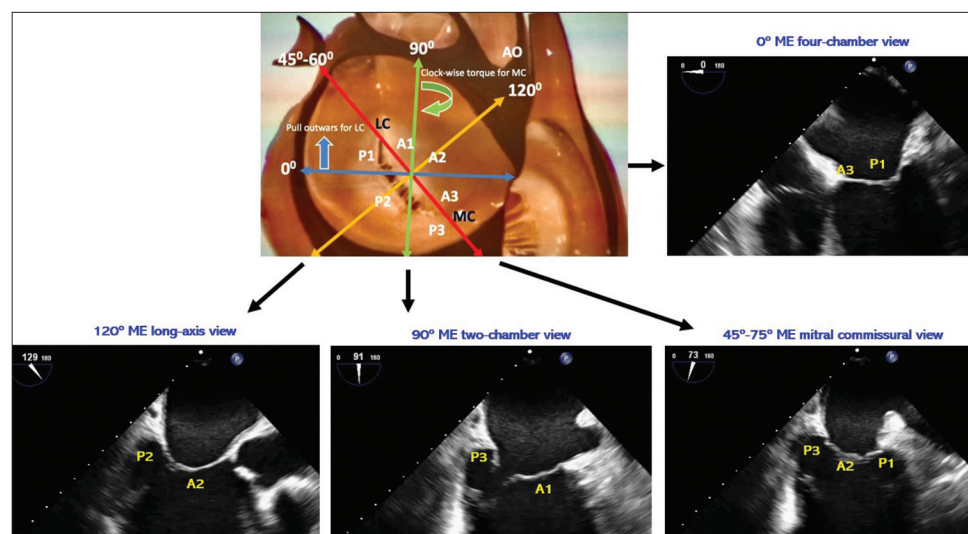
Two-dimensional transesophageal echocardiographic visualization of the mitral valve in different views. A1, A2, A3, P1, P2, and P3 are scallops of anterior and posterior mitral valve leaflets, respectively. Ao: Aorta, LC: Lateral commissure, MC: Medial commissure, ME: Mid-esophageal
